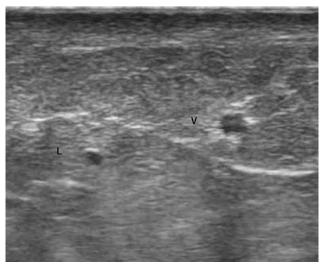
Ultrasonographic image of the lymphatic vessels (L) and subcutaneous veins (V). The hypo-echoic circles indicate the lumen of the vessels. The lymphatic vessels were dilated, indicating the stasis of the lymphatic fluid within the lymphatic vessels. The hyperechoic circles around the lumen indicate the vessel walls. The walls of the lymphatic vessels are thin and do not seem to be sclerosed.
